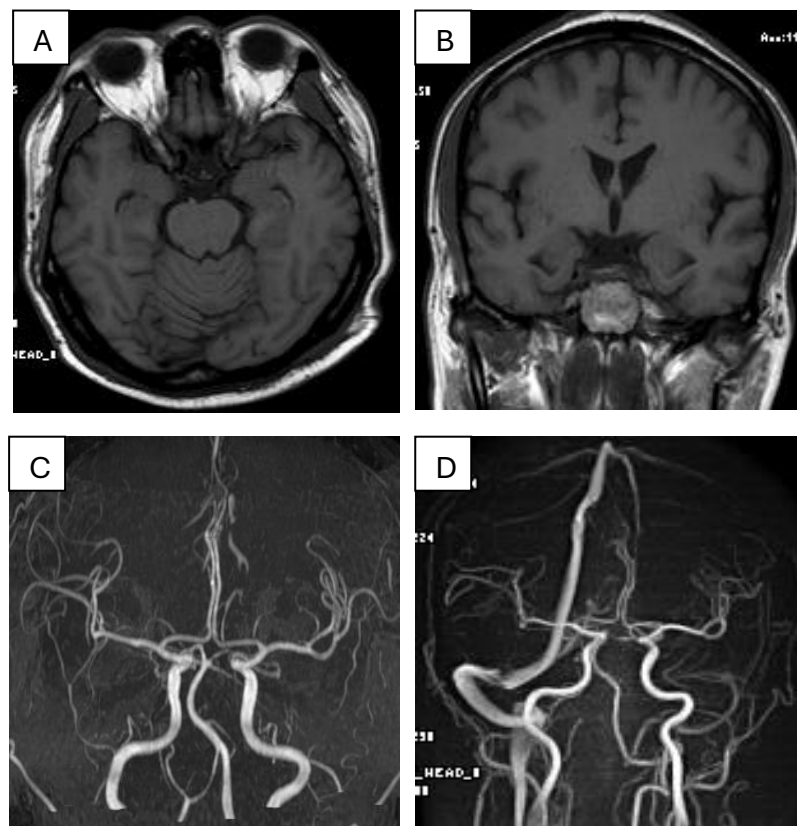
A and B. Axial and coronal section of head MRI showed no lesion in cavernous sinus. C and D. Angiography of carotid, intracranial artery and venous system showed no aneurysm and stenosis. Note the right dominance of transverse sinus.
